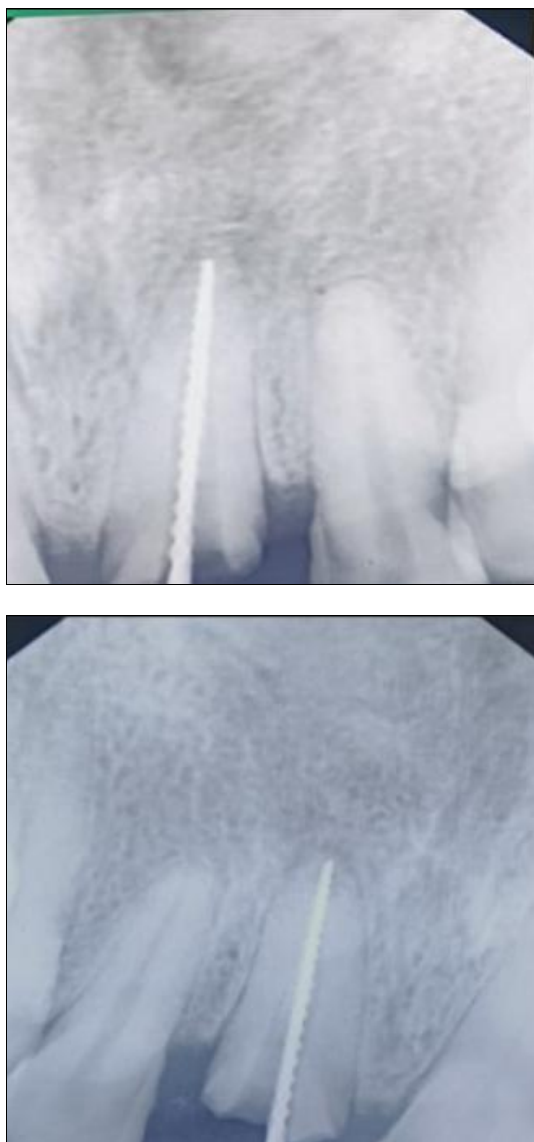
Radiographic evaluation of the working length after removal of previous obturation.
